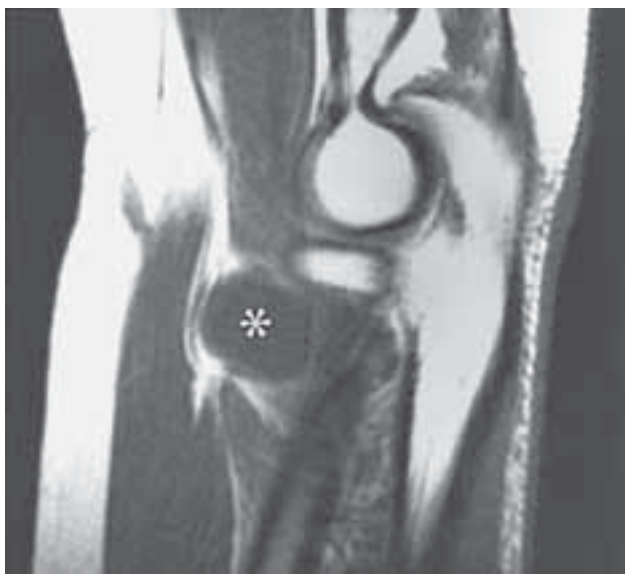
This patient had a near complete posterior interosseous nerve palsy associated with a 2.5 cm mass. Plain radiographs were unremarkable. Sagittal T1 (a)-weighted MR images show a mass (*) iso-intense to muscle in the region of the radial neck and the supinator muscle (S). (From Spinner, R. J., Lins, R. E., Collins, A. J., and Spinner, M.: Posterior interosseous nerve compression due to an enlarged bicipital bursa confirmed by MRI. *J. Hand Surg.* 18B:753, 1993.)
